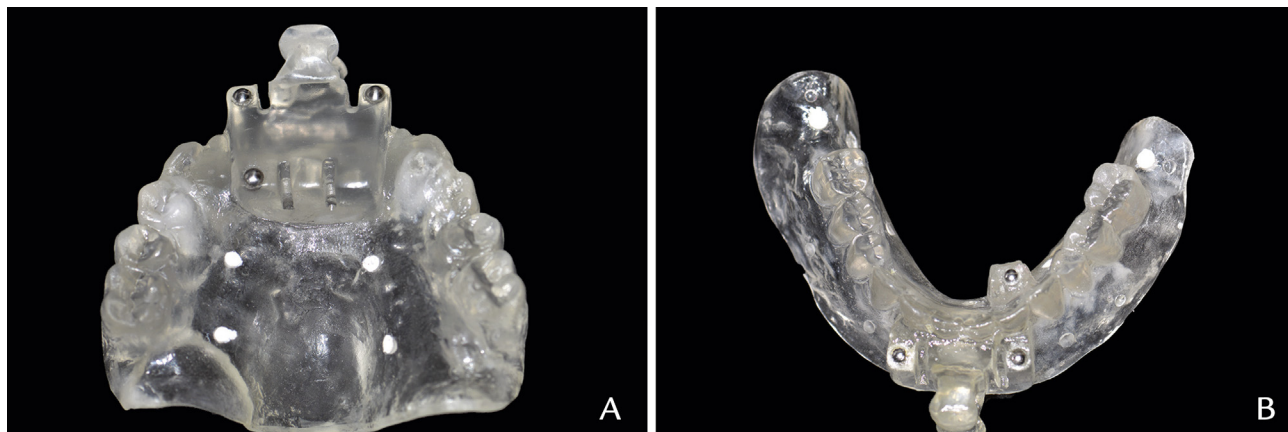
Radiographic stent (CP-Stent-R) with required tooth positions and fiducial radiopaque spheres and markers. A, Maxillary. B, Mandibular.
